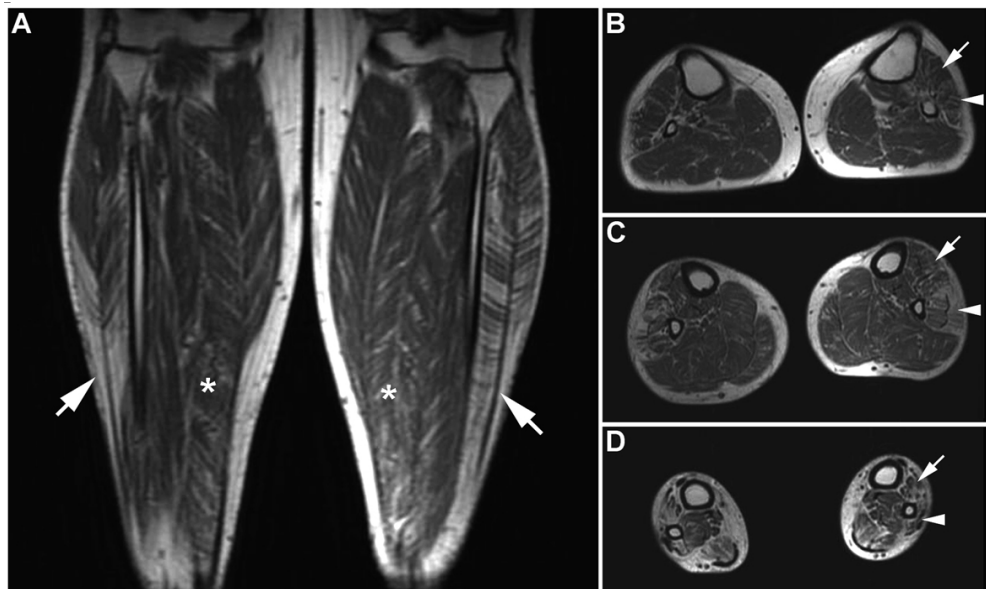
MRI study of the patient described in Figure 10 E-F.¹³⁴ A) T1-weighted coronal section of the legs showing extensive, striped fatty infiltration of the peroneal muscles, which is more pronounced in distal areas (arrows). The distal portion of the soleus muscles is less affected (asterisks). T1-weighted axial images (B, proximal third of the legs; C, middle third; D, distal third) showing predominantly distal fatty infiltration in the muscles of the anterior (arrows) and lateral (arrowheads) compartments; the posterior compartments are spared.
